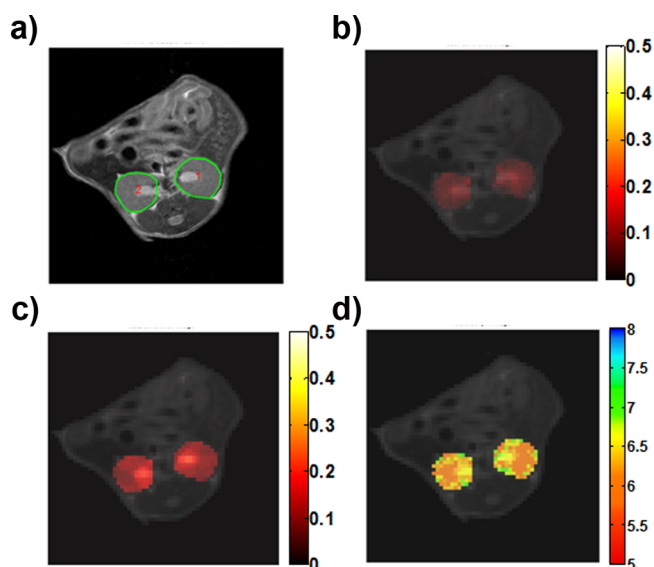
Renal CEST-MRI following iobitridol i.v. injection (1.5 g I/kg b.w.). (a) T_{2w} renal MRI. CEST ST difference map between pre-/post-injection at 1.5 μT (b) and 6 μT (c). (d) The pH map determined from RF power-based ratiometric pH imaging. Only kidney signal displayed in color on grayscale image to highlight effects.
